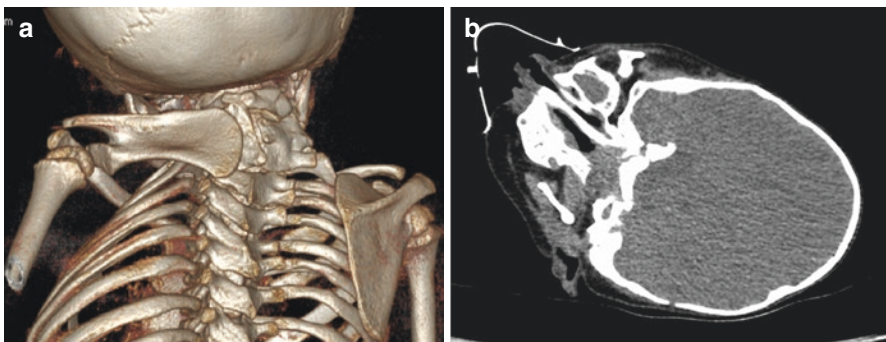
Osseous torticollis in a patient with Klippel-Feil syndrome and Sprengel's deformity (CT scan; a); severe plagiocephaly (CT scan; b)
